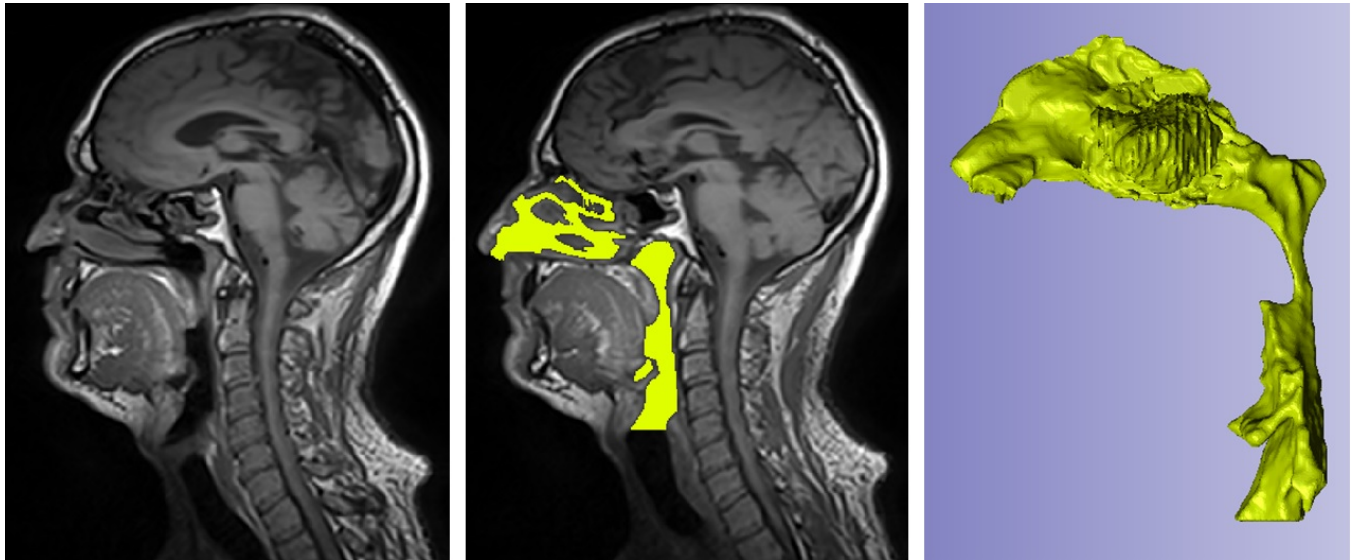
From left to right: MRI scan; Segmented nasal cavity; Extracted 3D model of the nasal cavity.
